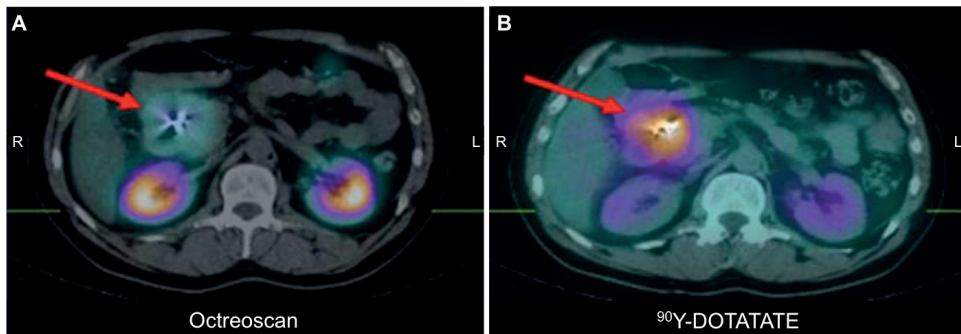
Coronal slices of fused SPECT-CT, showing uptake in the abdominal lesion (red arrow), the kidneys and the spleen. Images obtained 24 h after the injection of (A) Octreoscan® (185 MBq), (B) ^{90}Y -DOTATATE (1.7 GBq). Images adopted from Fabbri et al. (51).
